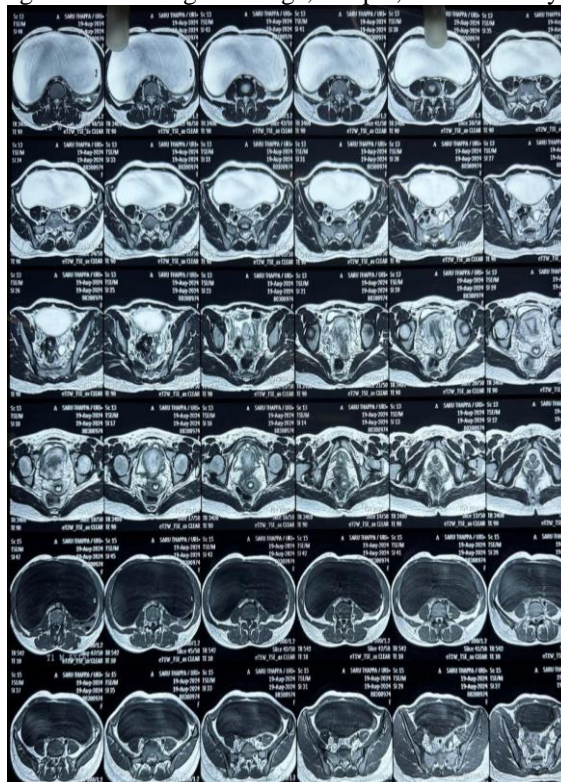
MRI showing large abdominopelvic cystic mass
